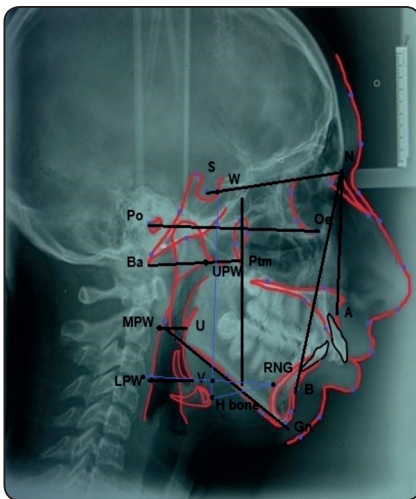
Showing pretreatment digital lateral cephalometric xray with reference planes and landmarks for the pharyngeal airway and hyoid bone measurements:
